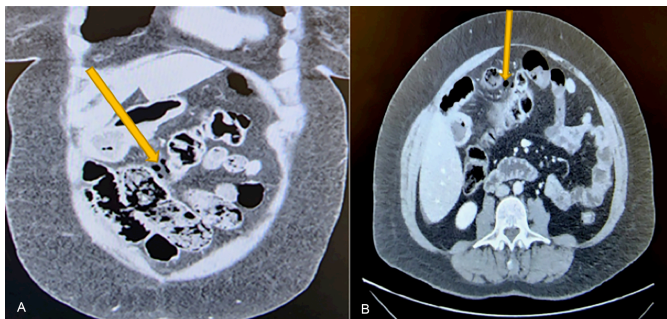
(A, B) Preoperative CT scan showing free air in the peritoneal cavity (arrows).
